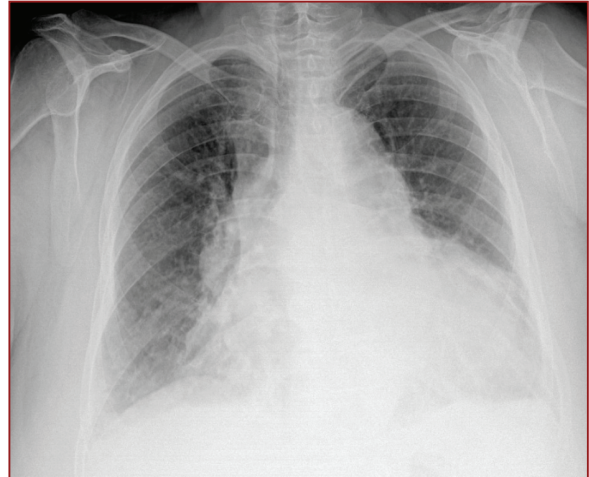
Patient's chest radiography.
